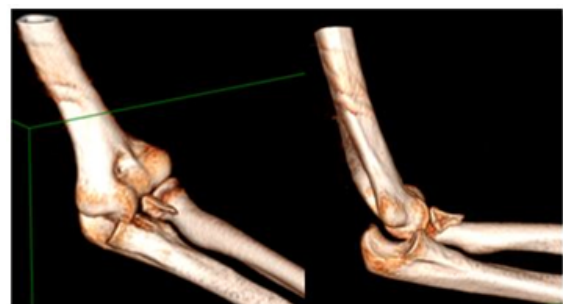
A three-dimensional reconstruction from the computed tomography scan of the left elbow demonstrates the fragment has arisen from the antero-lateral aspect of the ulna coronoid process.
